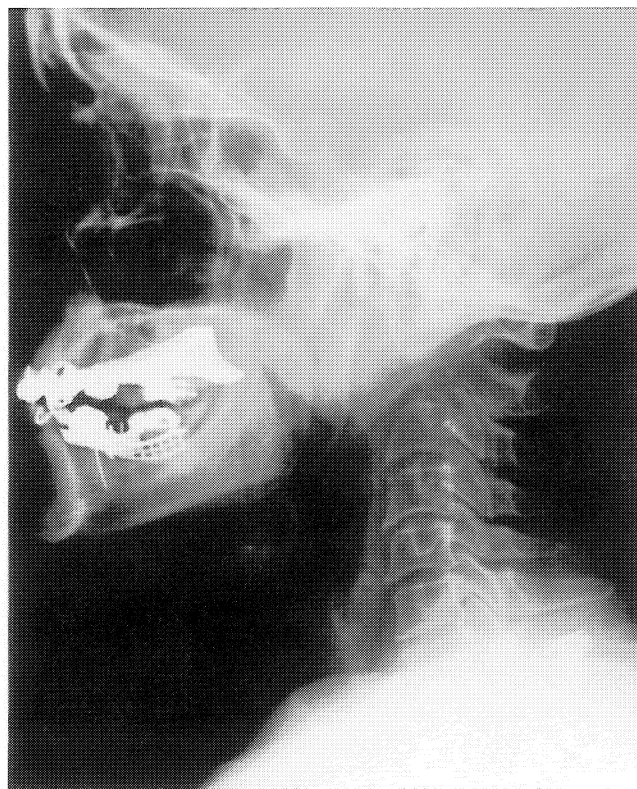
Initial lateral cervical spine radiograph. Resorption of the anterior portions of the atlas and axis with mild cranial settling is noted.
